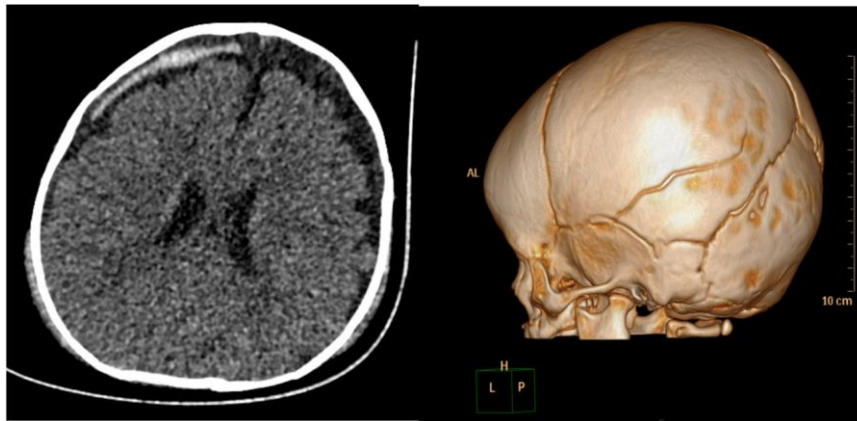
CT scan of a female infant showing a parietal skull fracture associated with subdural hemorrhage in the context of non-accidental trauma.
